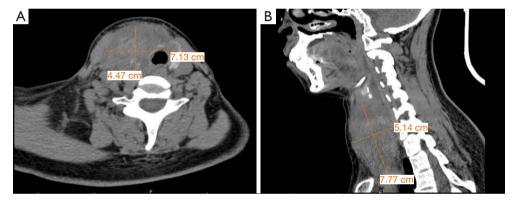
Axial (A) and sagittal (B) CT images of the mass preoperatively. CT, computed tomography.
